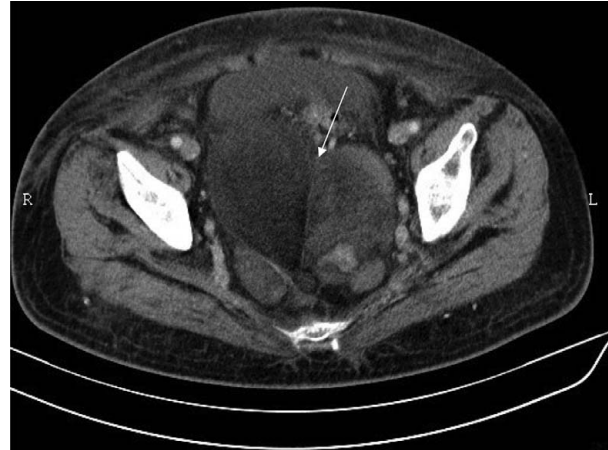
Pelvic contrast-enhanced computed tomography shows a well-circumscribed, presacral, soft-tissue mass. The arrow indicates the tumor.
